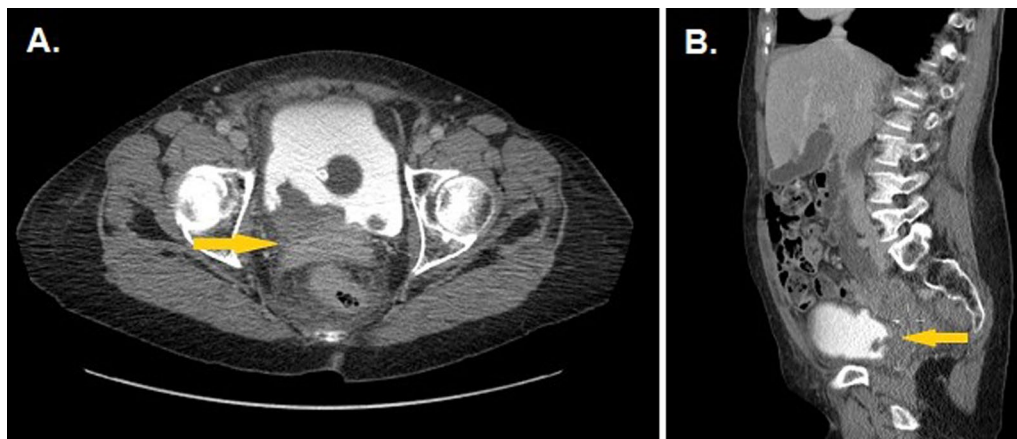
(Pre NACT): Axial (A) and sagittal (B) reconstructions from CECT in urographic phase showing a progression from previous CT with large filling defect in the right lateral aspect of the urinary bladder infiltrating into base of bladder and loss of fat plane between the lesion and uterine cervix (yellow arrow)
